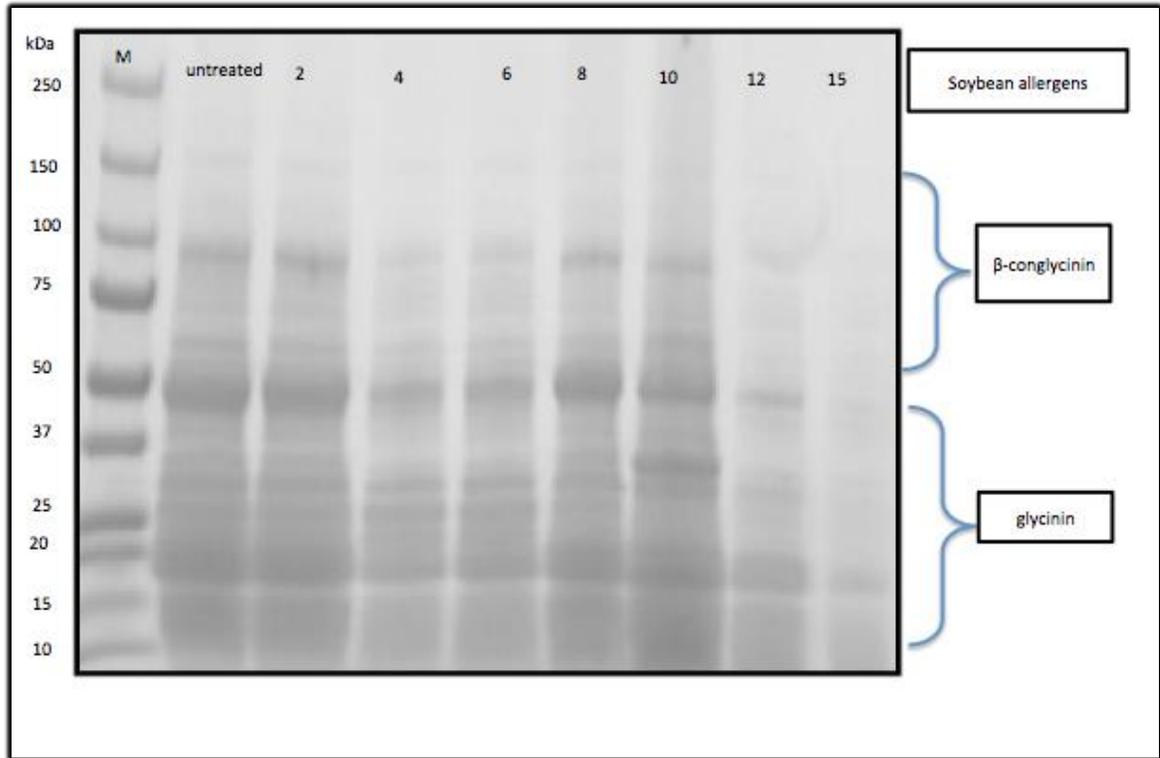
SDS-PAGE profile of soymilk treated with power ultrasound for 2, 4, 6, 8, 10, 12, and 15 min, compared to untreated soymilk. Molecular weights are expressed in kDa.
